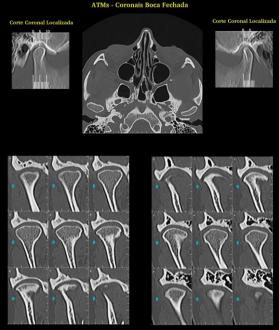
TC Cone Beam Mouth Closed
